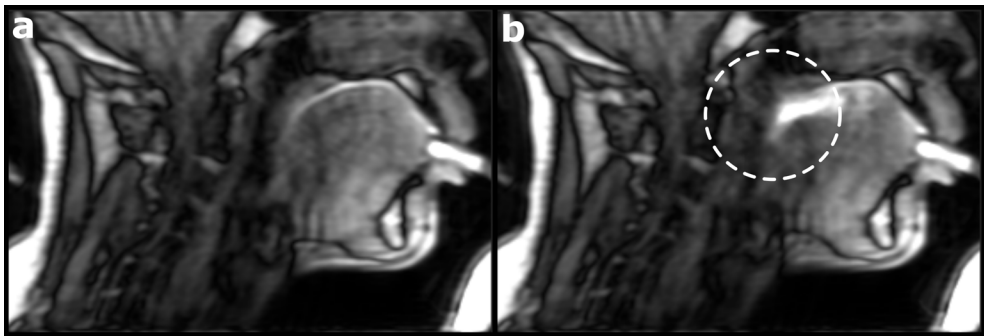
A sagittal slice of dynamic MRI of swallowing using a Cartesian pseudo-spiral acquisition pattern and reconstructed from multiple swallows of pineapple juice in a well-trained healthy volunteer. Although the image quality appear reasonably well at rest (a), during swallowing (b), the moving anatomical structures, such as the palate and the back of the tongue, have become blurred. The blurring was probably caused because the timing of the swallows was slightly off, or the motion was slightly different between swallows. For MRI of swallowing, a real-time acquisition would therefore be preferred. Note that a silicon tube was used to administer the pineapple juice to the volunteer, as multiple swallows were required without motion of the head.
